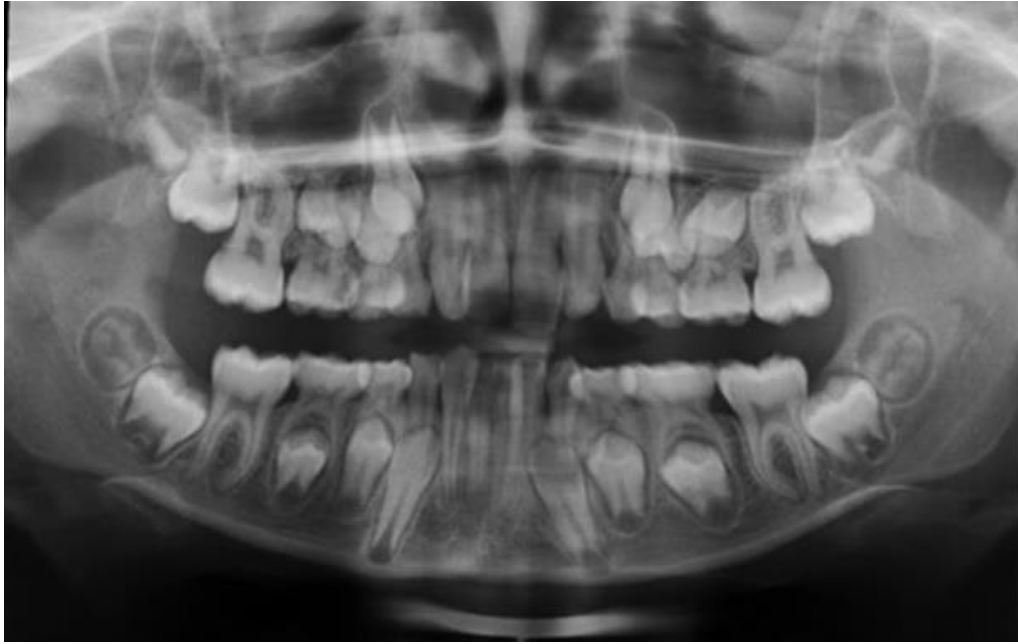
DPT radiograph of a patient showing lower second molars that are slightly mesioangular, but in a reasonable position. There is a dental delay elsewhere.
